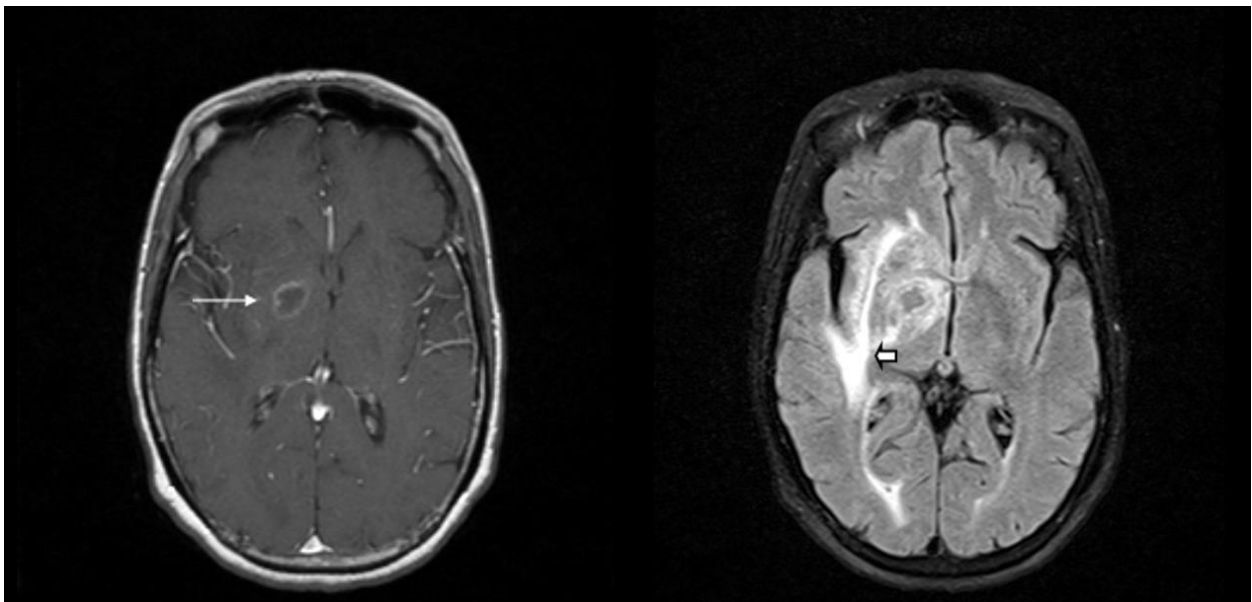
Axial postcontrast T1 image demonstrates a ring enhancing lesion present in the right basal ganglia (thin long arrow). On the FLAIR image there is adjacent high signal due to vasogenic edema (short arrow). Lesion was determined to be toxoplasmosis in a patient with HIV.
